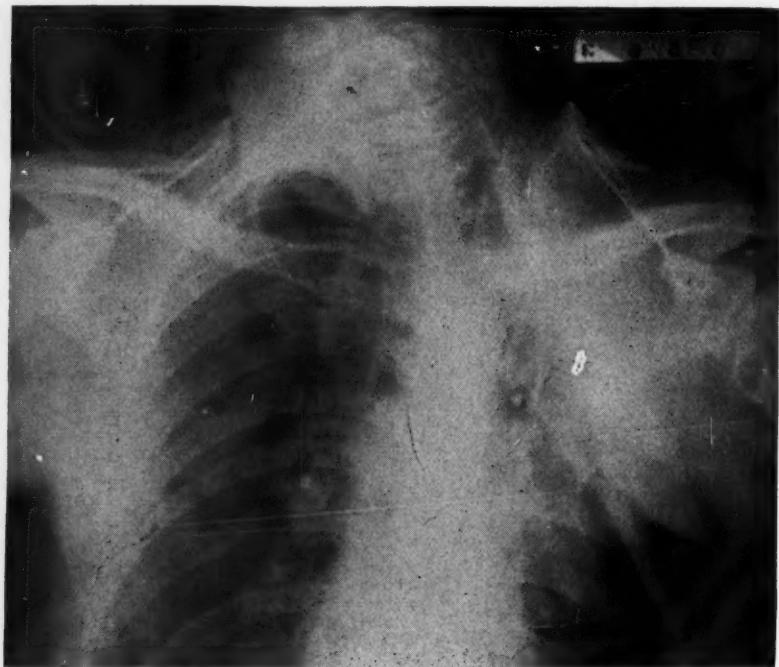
Case 1. September 29, 1945: Roentgenogram showing amount of collapse, and regeneration of ribs, which add support to the chest wall. No evidence of abscess cavity.
